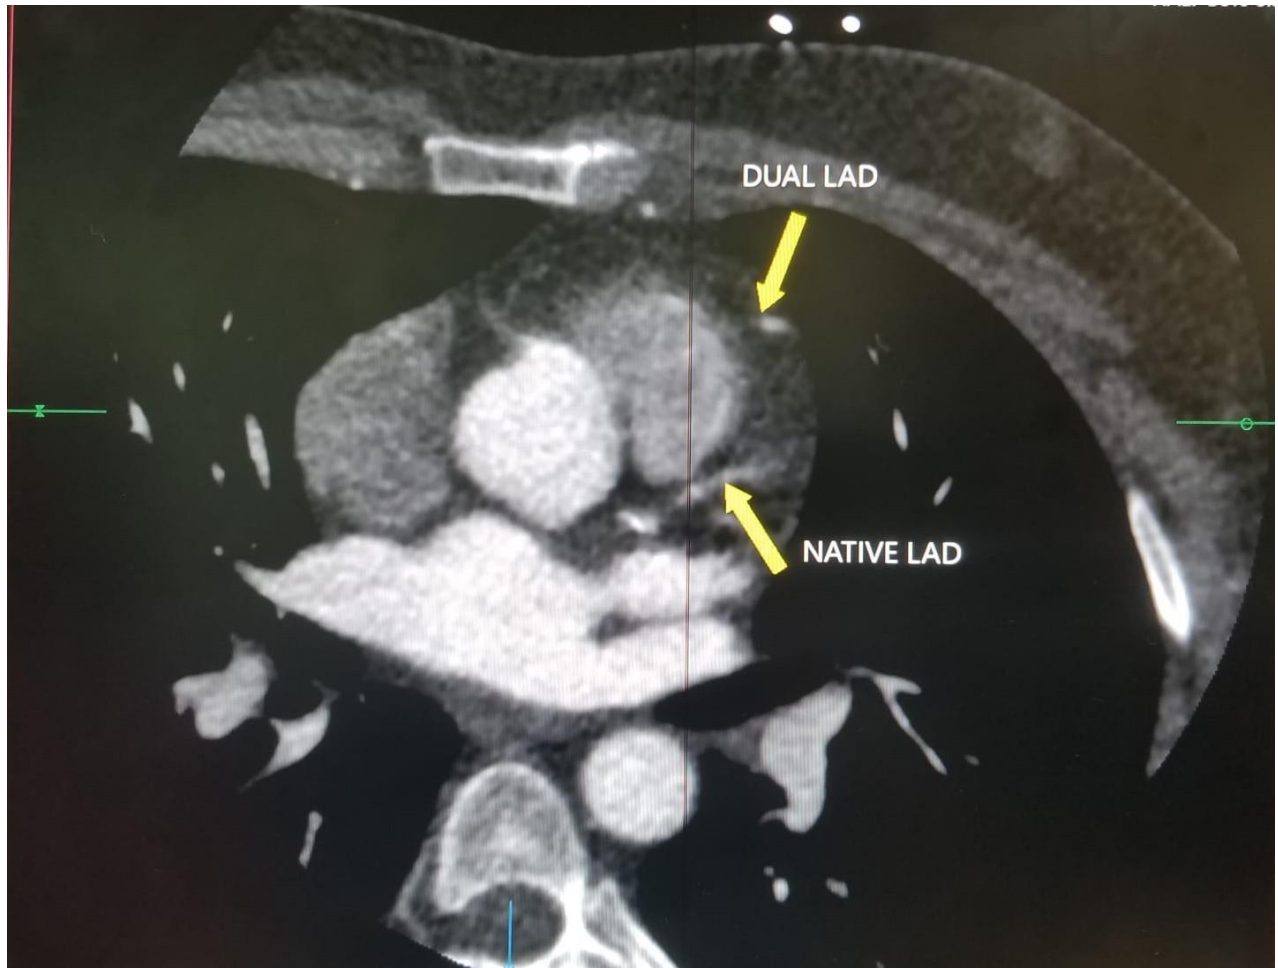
CT image showing dual LAD.
